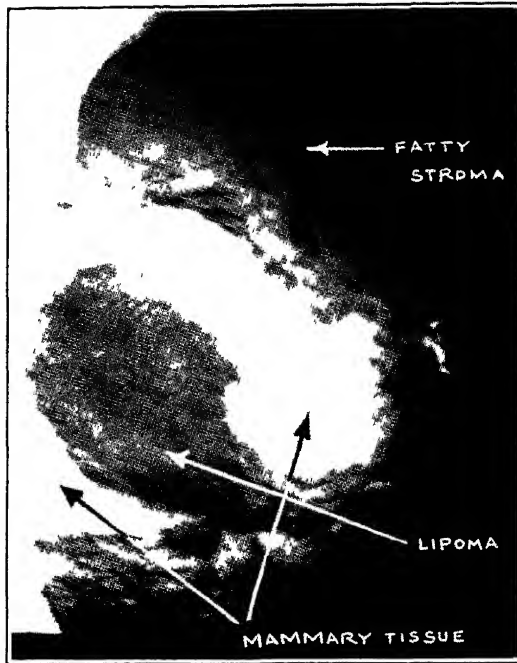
Lipoma The white homogenous matrix is being displaced by a large encapsulated tumor which has the same radiolucency as the fatty tissue stroma (Am J Roentgenol, March, 1938)
